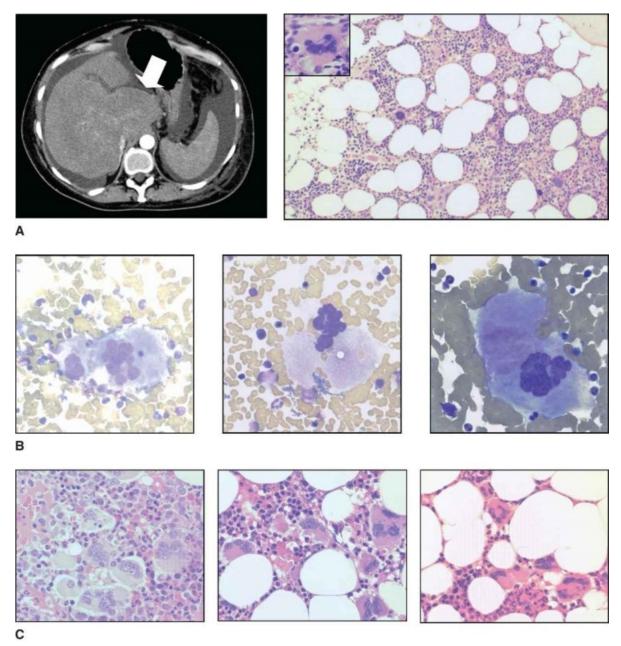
Morphologic features of essential thrombocythemia. A. Contrast-enhanced abdominal computed tomography (CT) scan showing features of established hepatic vein thrombosis in a 53-year-old woman, including hypertrophy of the caudate lobe
